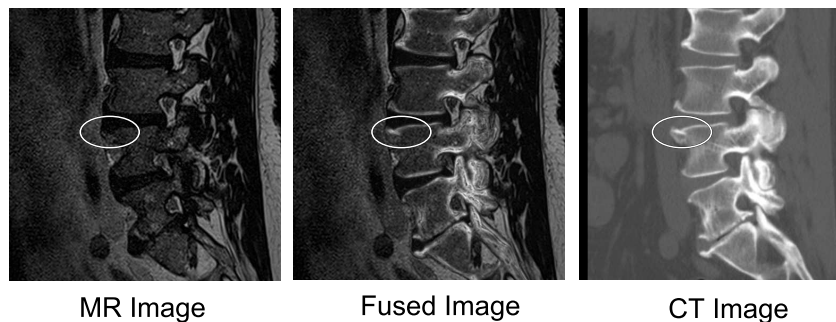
Images of bony spur formation: left - in the MR, the osteophyte is not identifiable; middle - in the fused image, the osteophyte is clearly visible along with the surrounding soft tissue; right - the CT image shows the osteophyte, but not the soft tissue.
